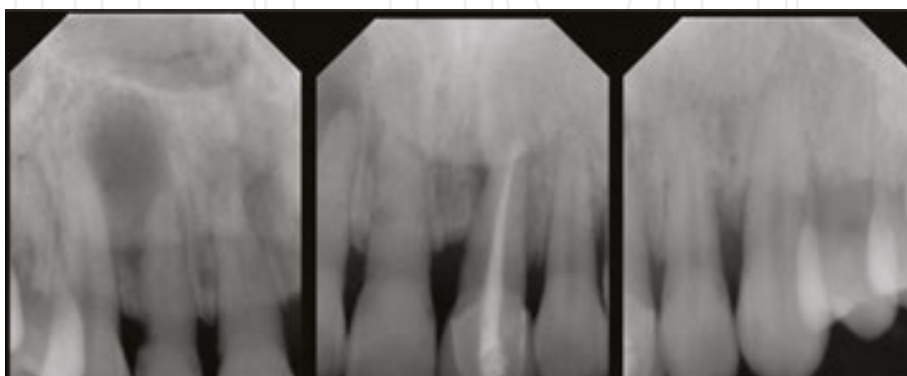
Periapical radiographs of the region.
